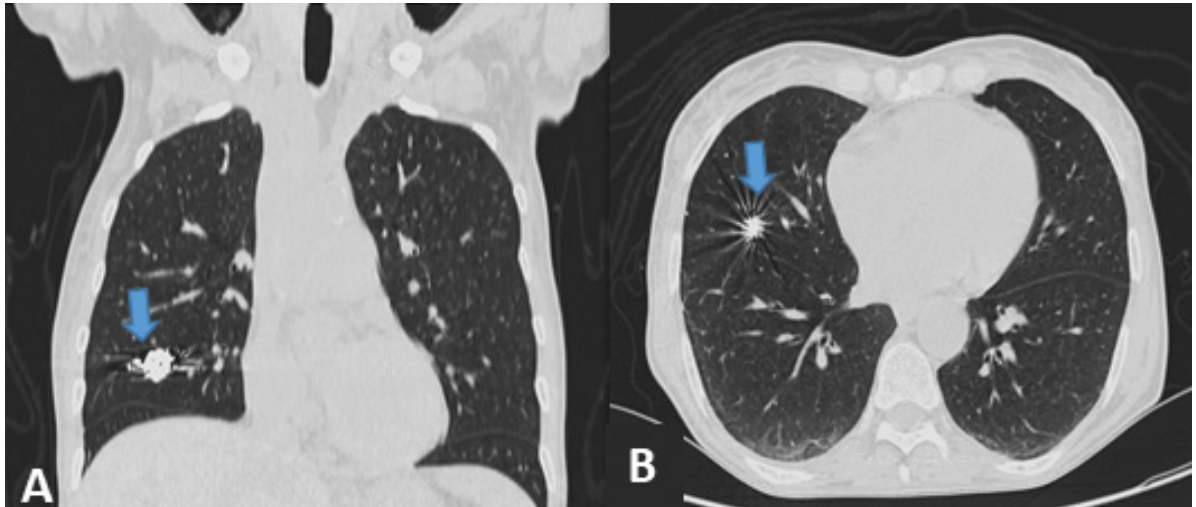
Coronal (A) and axial (B) views of thoracic multislice computed tomography images of pulmonary window showing the presence of coils and lack of aneurysmal sac opacification (blue arrow).
